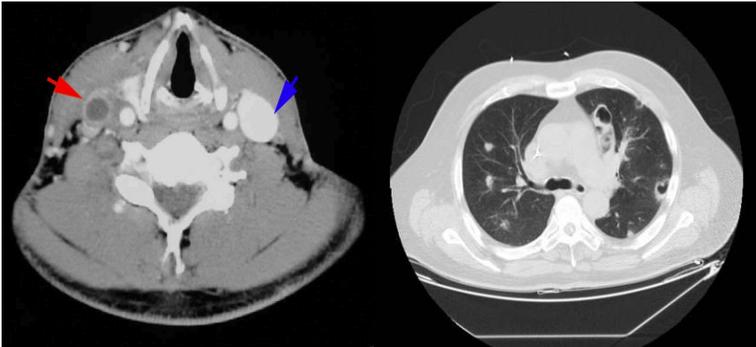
Demonstrates a thrombus in the right internal jugular vein on CT scan that is classic for Lemierre syndrome.
